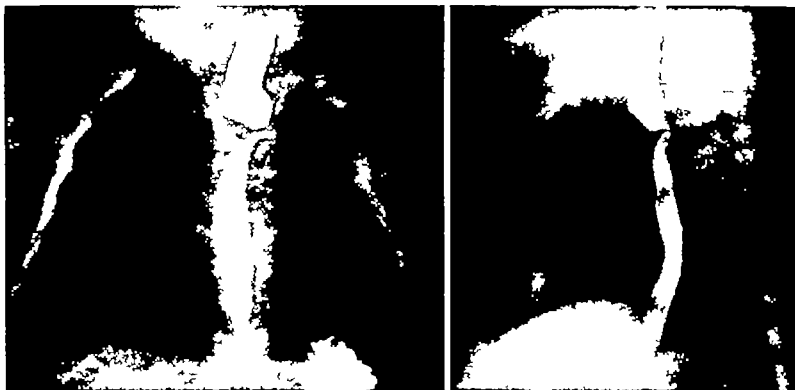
Roentgenographic examination following the ingestion of rugar 4 months after operation. The upper portion of the esophagus is moderately dilated, and a short narrow stricture is present at the site of the anastomosis as a result of healing by second intention. The lumen of the esophagus in the region of the stricture has a pronounced cork-screw curve, as seen in the frontal projection.
